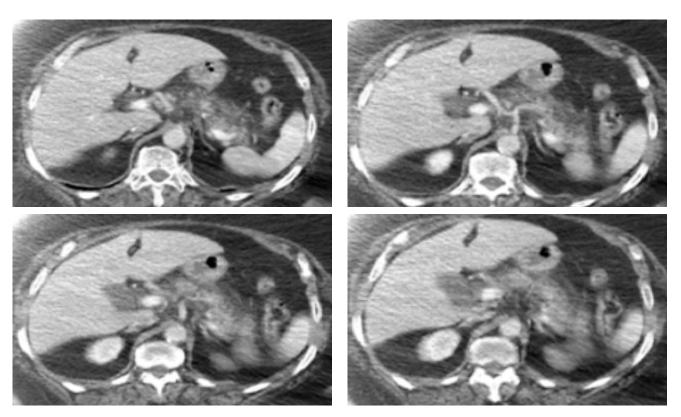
Abdominal CT showed fluid and inflammatory density increase were seen in the peripancreatic region.
